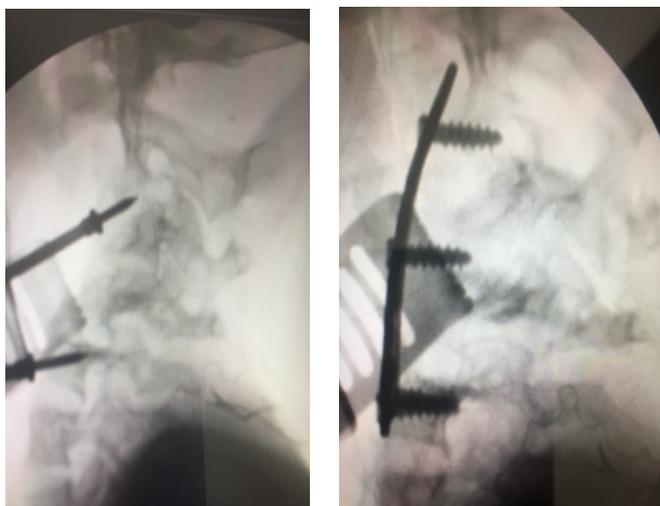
Per-operative X-ray after traction with 4kgs demonstrating good alignment (a) plating with graft C2-C5 (b)
